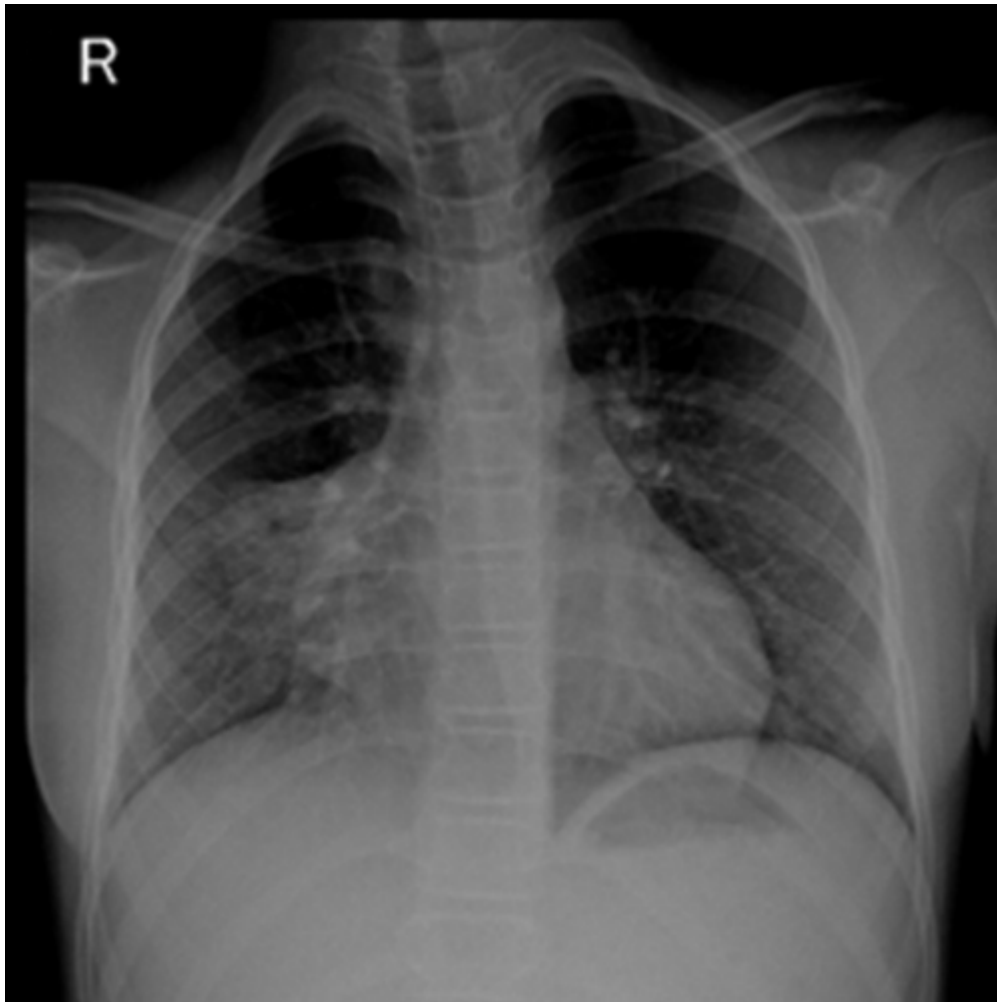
Chest X-ray from 24 March 2024 showing an inhomogeneous opacity located in the lower half of the right hemithorax, which obscured the right cardiac silhouette, with resolution of the previous pleural effusion. ↩
